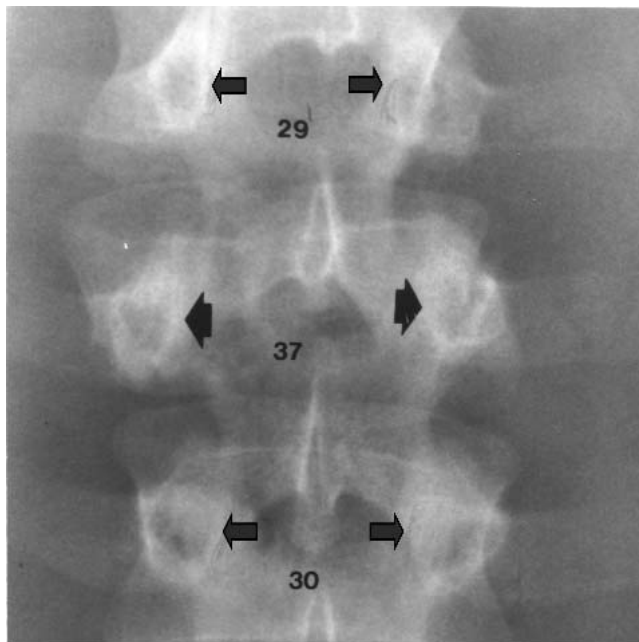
AP spine X-ray demonstrating widening of the interpedicular distance at the fractured level. The arrows point to the pedicles and the numbers represent the interpedicular distance.
